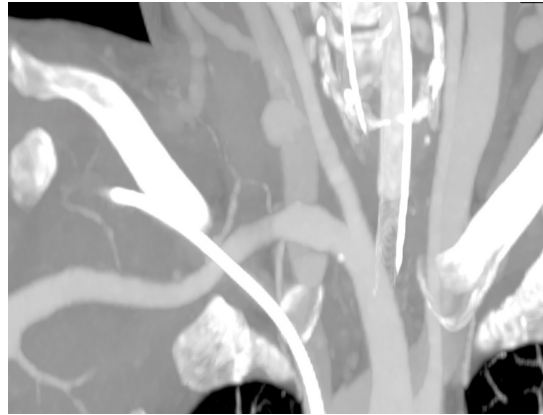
CT scan multiplanar reconstruction of carotid artery pseudoaneurysm.
